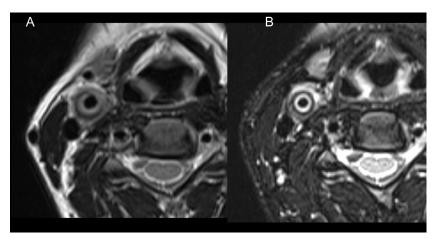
(A and B) T2-weighted axial images confirmed concentric thickening of right common carotid artery and internal carotid artery, with hyperintensity in the intima-media complex, low signal in the adventitia, and hyperintensity in the perivascular tissues.
